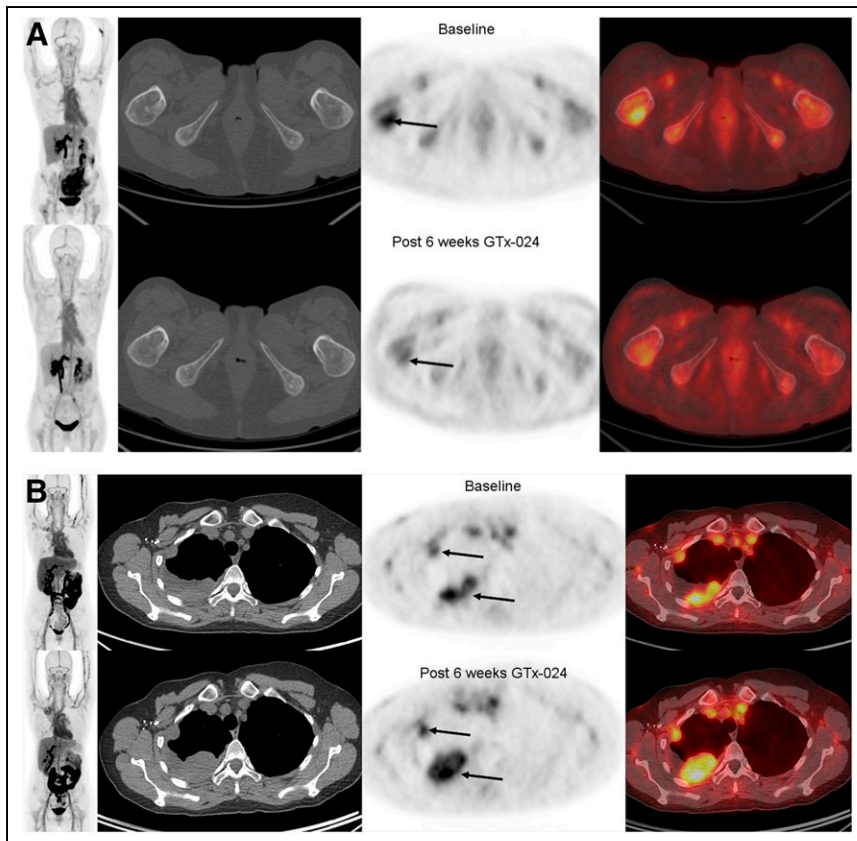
(A, left-most panel: maximum-intensity-projection PET; 2nd panel: axial CT; 3rd panel: axial PET; 4th panel: axial fused PET/CT) ^{18}F -FDHT-avid AR+ tumor at baseline (top row, arrow [SUV_{max}, 4.9]) and decline in ^{18}F -FDHT uptake 6 wk after starting GTX-024 (bottom row, arrow). Best overall response was stable disease 12 wk after starting therapy. (B, left-most panel: maximum-intensity-projection PET; 2nd panel: axial CT; 3rd panel: axial PET; 4th panel: axial fused PET/CT) ^{18}F -FDHT-avid AR+ tumor at baseline (top row, lower arrow [SUV_{max}, 5.1]) and no decline in ^{18}F -FDHT uptake and increased tumor size 6 wk after starting GTX-024 (bottom row, arrows). Best overall response was PD 12 wk after starting therapy.
